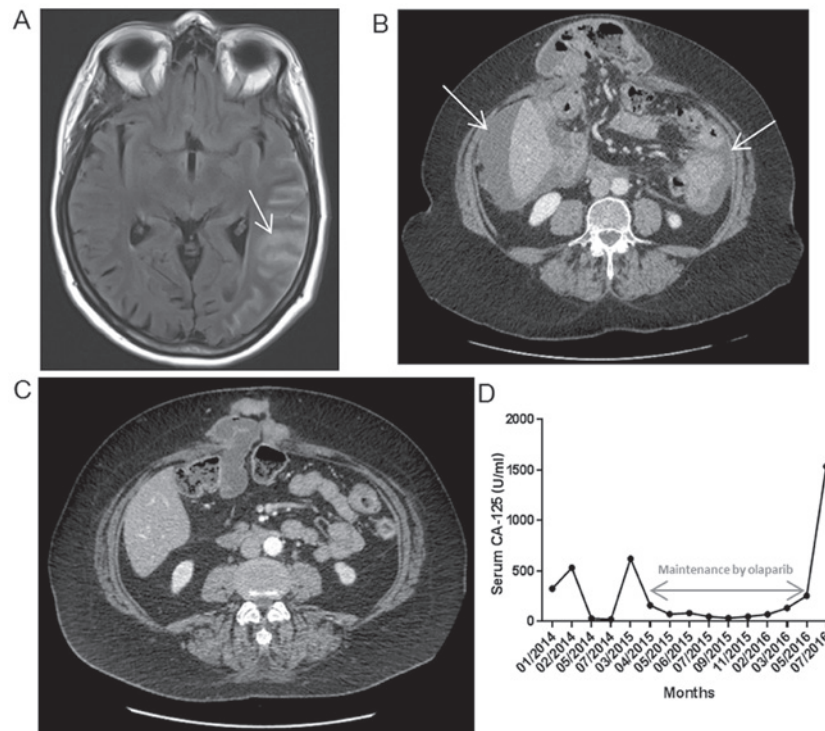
Imagery and biological exams performed throughout medical care. (A) MRI showing nodular meningitis (white arrow). (B) CT scan exam indicating the presence of an abundant ascites liquid quantity (white arrows). (C) CT scan exam showing the complete disappearance of ascites after platinum-based chemotherapy. (D) Serum CA-125 dosage throughout the maintenance by olaparib treatment. MRI, magnetic resonance imaging; CT, computed tomography.
